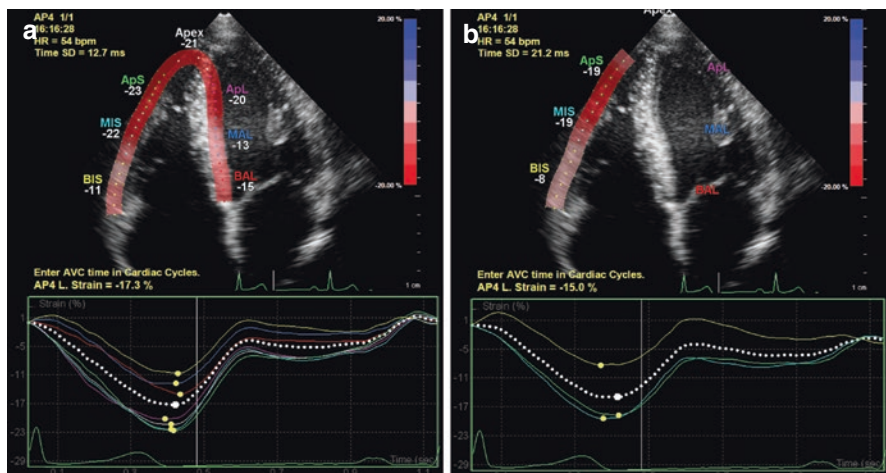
Peak values of 2D longitudinal speckle tracking derived strain is assessed in the RV focused apical four-chamber view. In the literature, RV strain and strain rate is assessed as the averaged of all segments of the free wall and interventricular septum (a) or the three segments of the RV free wall (b)
